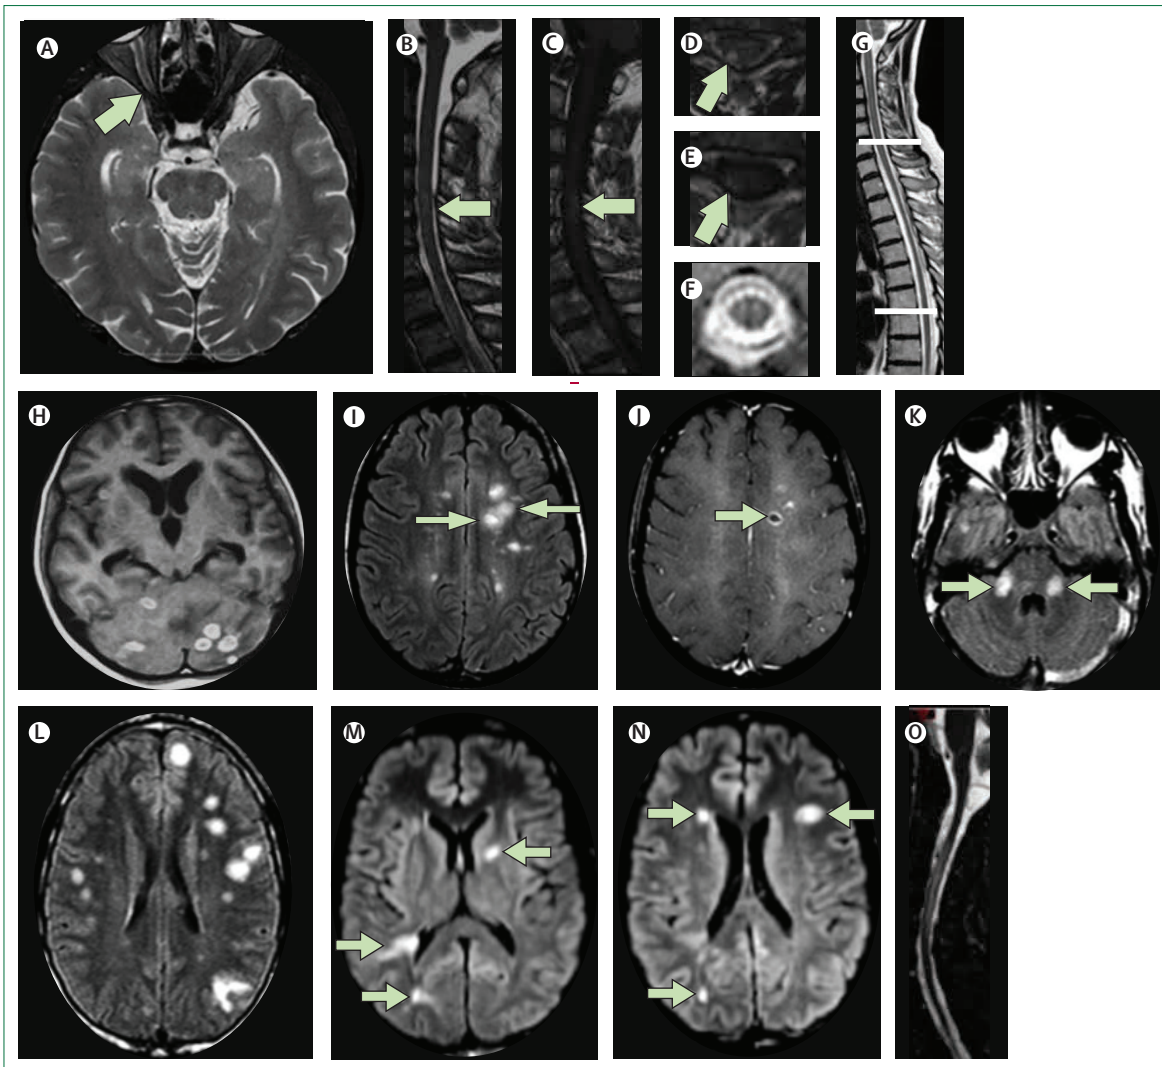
MRI scans of infectious diseases that mimic multiple sclerosis
